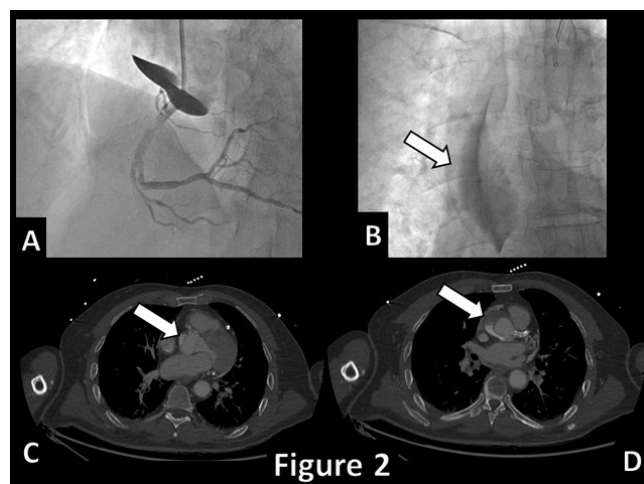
Coronary angiogram with rapid onset and extension of ascending aorta dissection (A & B, arrow) confirmed at an urgent computed tomography scan (C & D, arrows).
